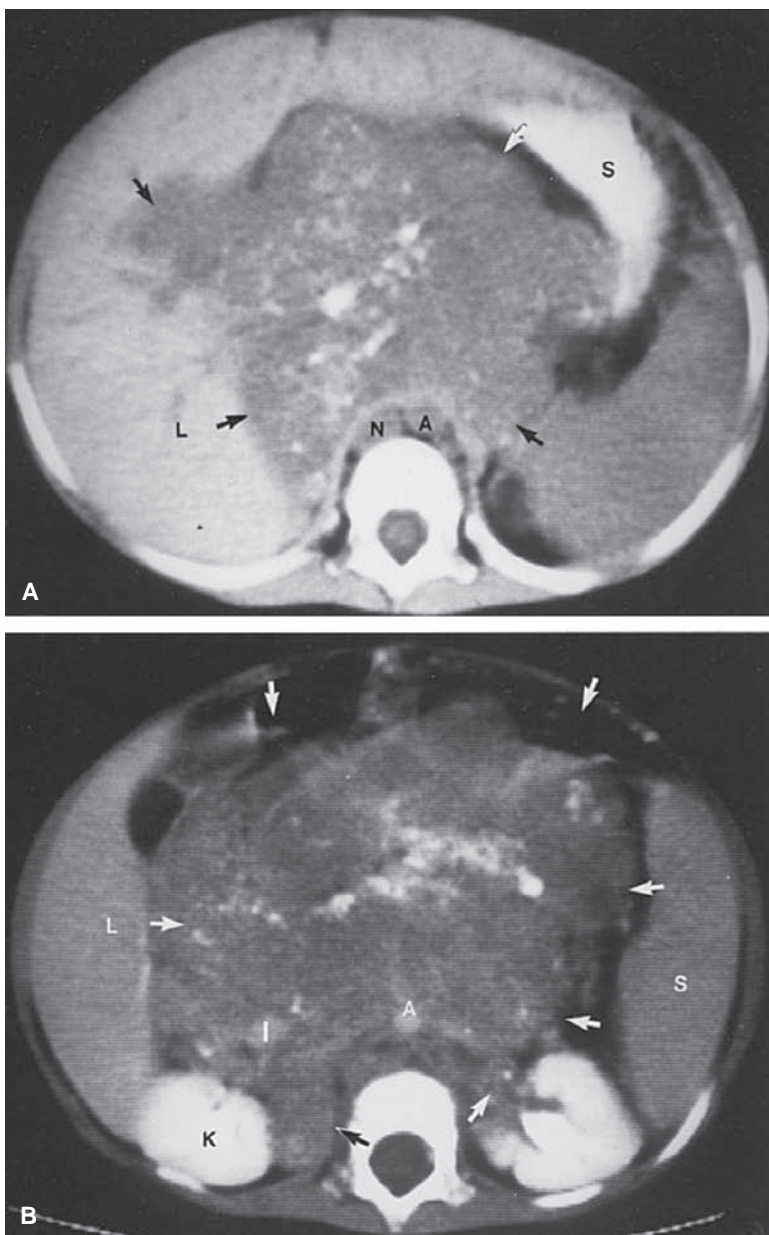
A: Celiac axis neuroblastoma. Computed tomographic (CT) section of the abdomen shows a large lobulated mass with multiple flakes of calcification displacing stomach and the liver (*white arrow*). Note presence of retrocrural node (*black arrows*). A, aorta; L, liver; N, node; S, stomach. B: Celiac axis neuroblastoma. Enhanced CT section of the abdomen at level of the kidney shows a large lobulated mass with irregular margins and calcification displacing the right kidney inferoposterior and laterally. Note encased inferior vena cava (IVC) and aorta. The IVC is displaced laterally and ventrally and to the right the superior mesenteric artery and celiac axis are completely surrounded by the mass. A, aorta; I, IVC; K, kidney; L, liver; S, spleen; *white arrows*, mass.
